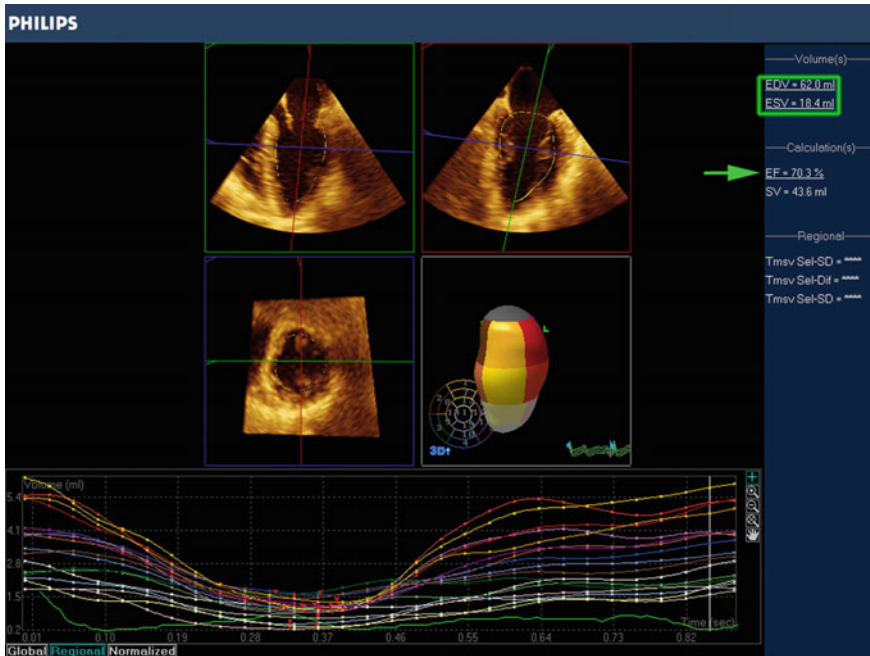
Calculation of EF using 3D echocardiography. The *individual lines* represent contribution from all LV segments. The global EF is displayed on the *panel to the right* (green arrow)
